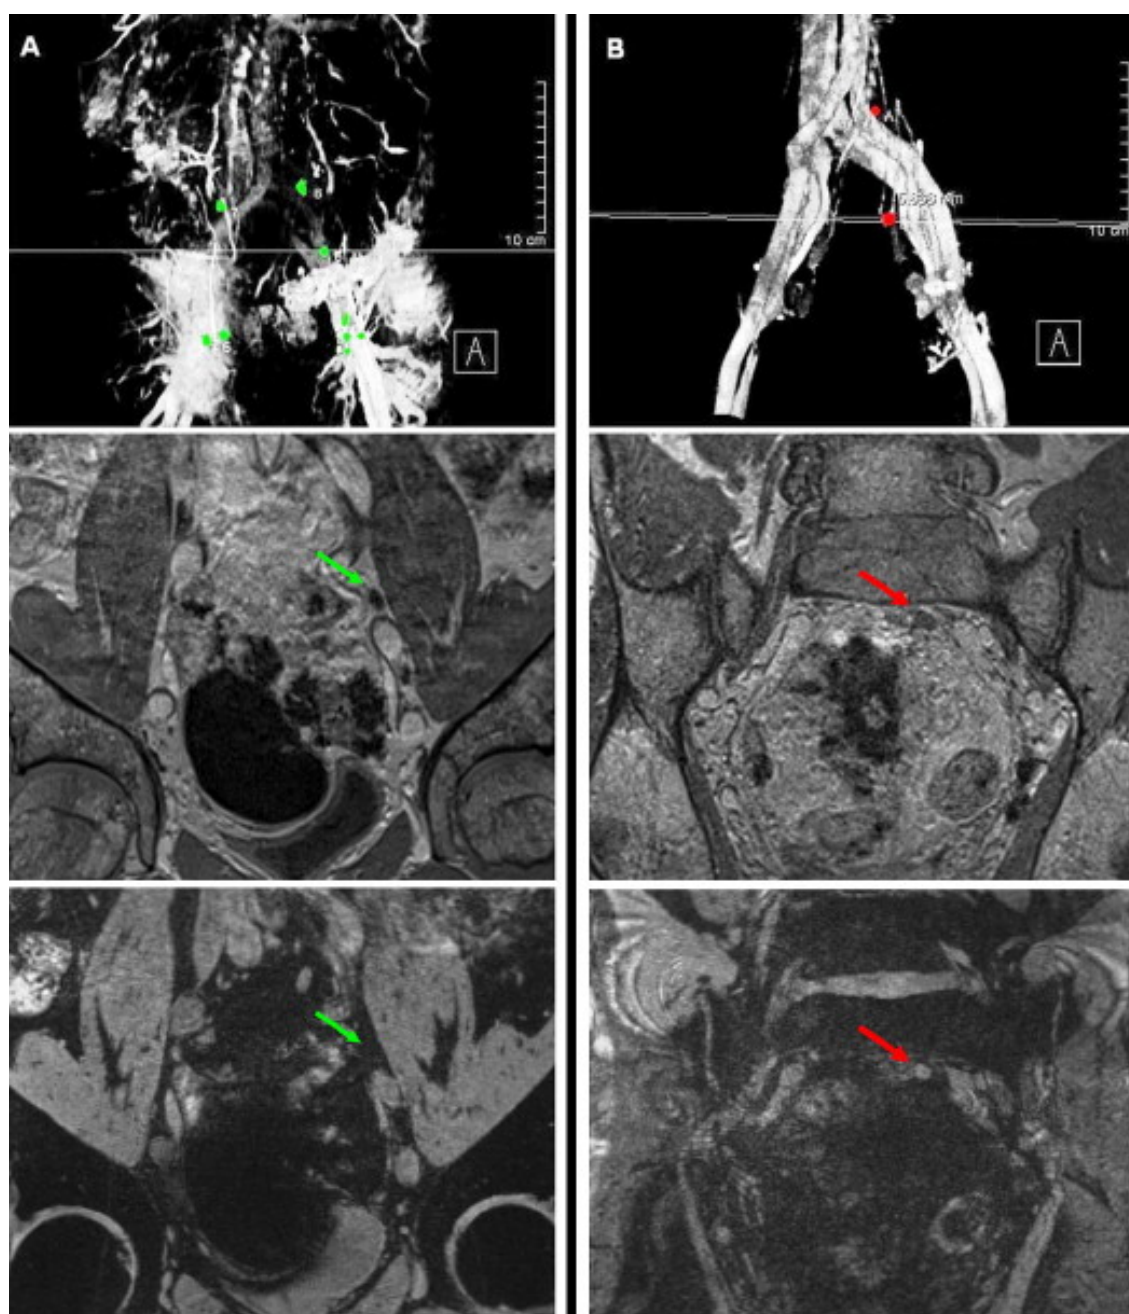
(A) Example of a negative magnetic resonance lymphography in a patient with a score on the Stephenson nomogram of 87 points. (B) Example of a positive magnetic resonance lymphography in a patient with a score on the Stephenson nomogram of 267 points. Above, Lymph nodes mapped in relation to the vessels. The negative lymph nodes are marked green, the positive red. Center, T1-weighted images, showing good visualization of lymph nodes (arrows). Below, The same lymph nodes on a T2*- weighted image. In (A) the lymph node is now indistinguishable from the surrounding adipose tissue because it has a low signal intensity owing to accumulation of the iron oxide particles, which identifies the lymph node as negative. The lymph node in (B) has a high signal intensity on this T2*-weighted image, which means that accumulation of the iron oxide particles has been blocked and the lymph node is positive.
